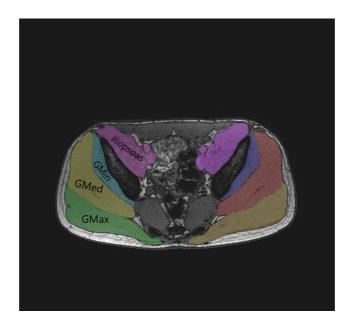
Typical T1-weighted magnetic resonance image (MRI) displaying the cross-sectional areas (CSAs) of the gluteus maximus (GMAX), gluteus medius (GMED), gluteus minimus (GMIN), and iliopsoas (ILIOP).
